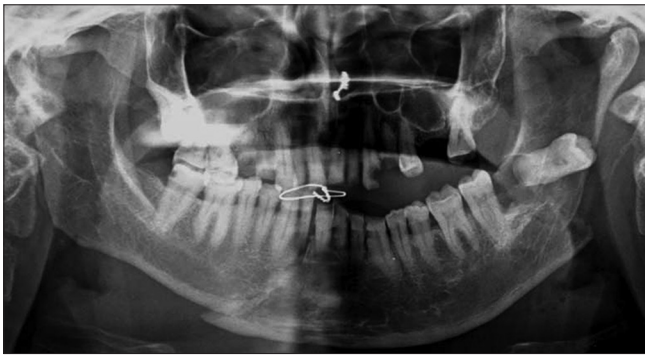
Orthopantomogram showing right parasymphysis, left angle fracture and displaced lower third molar
